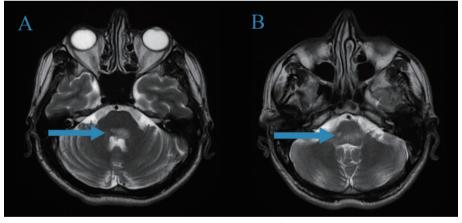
Lesion in the pons ventral region in MRI T2 sequence
